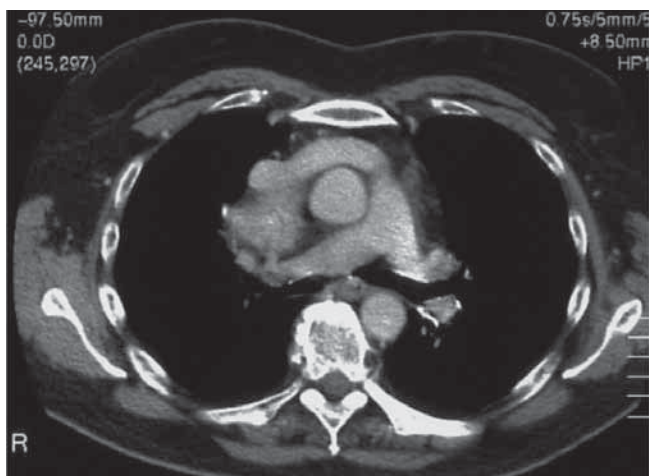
Axial CT scan showing presence of ectopic intra-thoracic thyroid nodule. The mass is located below the tracheal carina, reaching the pulmonary artery bifurcation.
